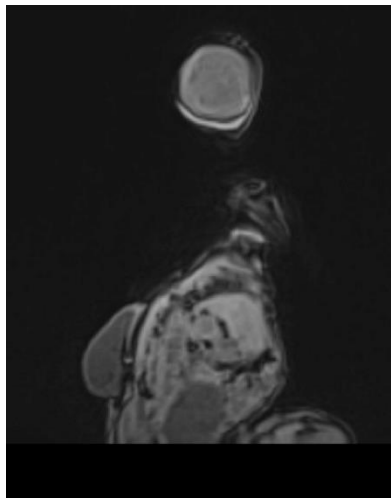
MRI coronal/axial view demonstrating the lesion's extent and mass effect, highlighting the need for differentiation from spinal dysraphism.
